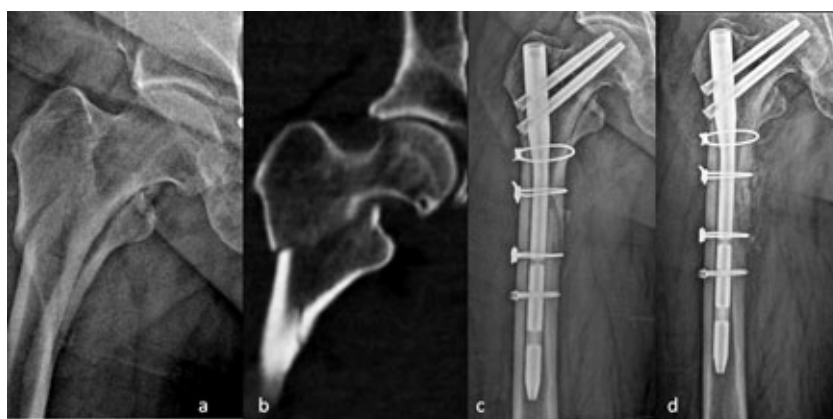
(a) Preoperative X-ray of a 60-year-old male showing an AO 31 A3.3 unstable fracture. (b) Computed tomography image verifying the A3.3 type fracture. (c) Early postoperative anteroposterior (AP) X-ray showing excellent reduction obtained via an open intervention of the fracture. (d) AP X-ray showing union at 13 months postoperatively.
